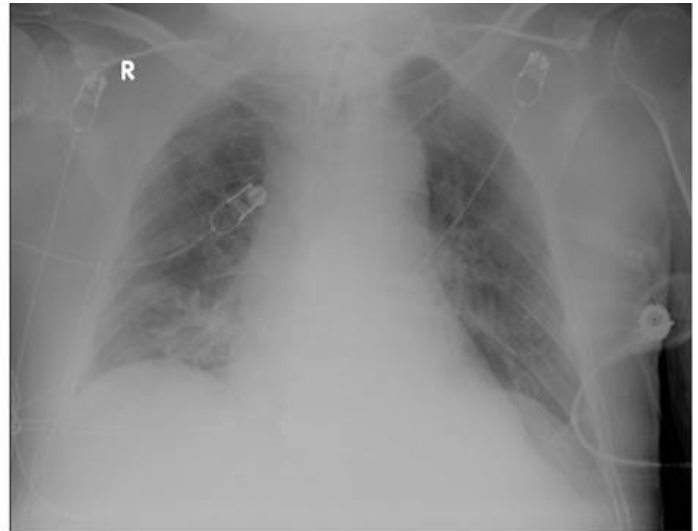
Repeat chest x-ray after two weeks therapy with the triple antibiotics showed near complete resolution of infiltrates.
